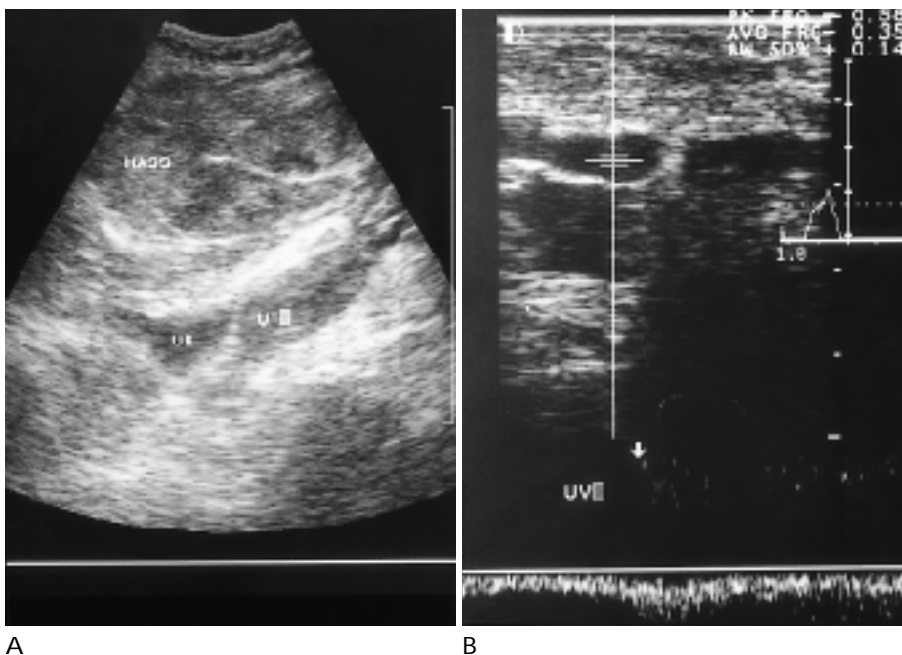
A. Transverse sonogram in lower abdomen shows heterogeneous hyperechoic mass of hematoma in lower abdominal cavity. B. Longitudinal sonogram shows dilated paraumbilical vein in abdominal wall.
